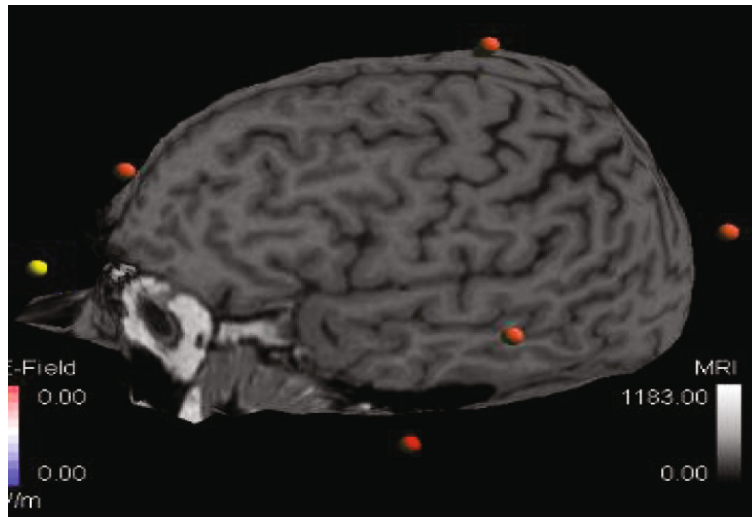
Reported findings of the current MRI noted two small areas of low signal intensity involving the subcortical white matter of the left occipital lobe and the left temporal lobe which were compatible with small areas of brain parenchymal loss.
